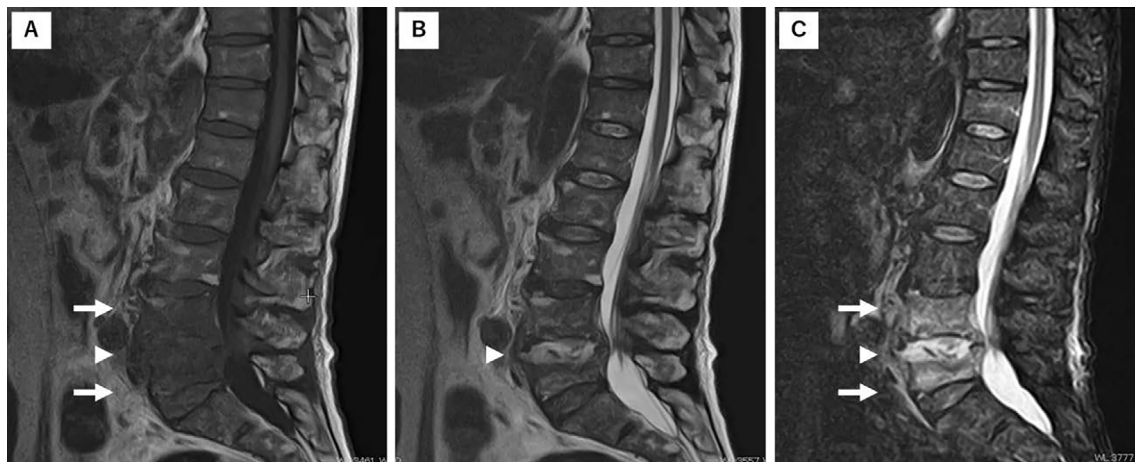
MRI of the lumbar spine. (A) T1-weighted image shows decreased signal intensity in the L4 and L5 vertebral bodies (arrows) and loss of end plate definition (arrow head). (B) T2-weighted image demonstrates increased signal in the L4/L5 interval disc space (arrow head). (C) Short tau inversion recovery image shows increased signal in the intervertebral disc space (arrow head) and adjacent L4 and L5 vertebral bodies (arrows). MRI: magnetic resonance imaging
